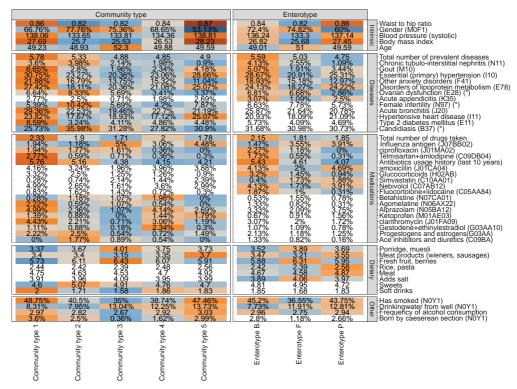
Associations with the enterotype (ET) model and community type (CT) model. Colored cells represent factor associated with CT and ET models respectively (FDR ≤ 0.1), white cells indicate no statistically significant association (FDR ≥ 0.1). Blue colors indicate lower mean values or proportions for the cluster and orange color indicate higher values. Mean values or proportions (indicated by %) per cluster are shown. Asterix (*) in the names of the factors indicate that a subpopulation consisting of women was used for calculating the displayed value.
